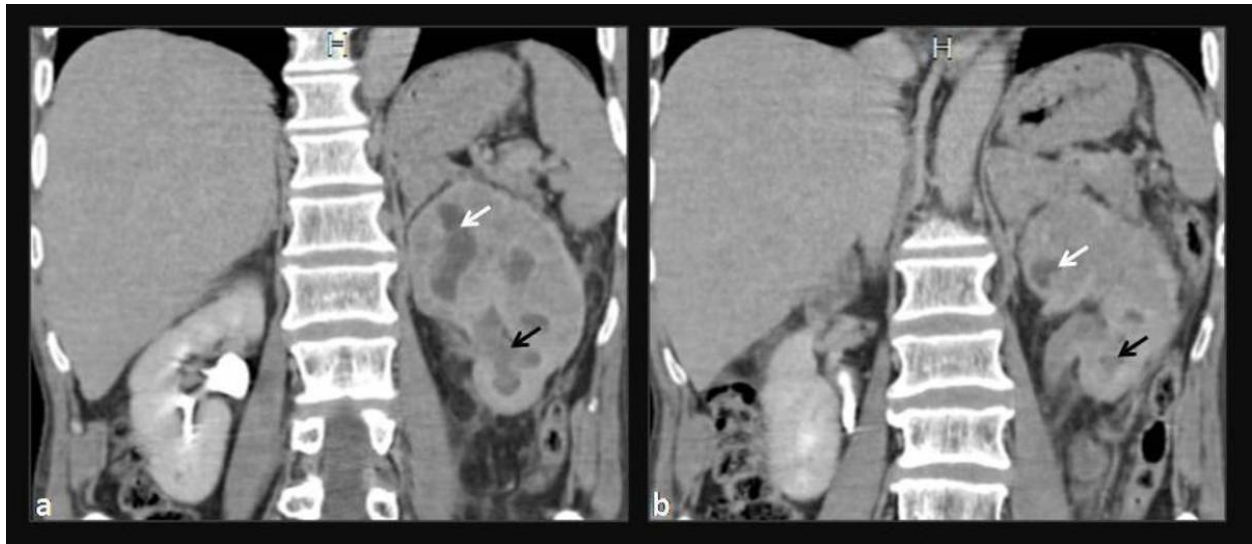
Multiple renal abscesses (same case as in fig. 11). Coronal contrast-enhanced CT images show an enlarged and heterogeneous left kidney, with multiple hypodense collections representing abscesses (white arrows). There is also dilatation of several calyces in the lower pole, which are filled with dense material (pyonephrosis) (black arrows).
